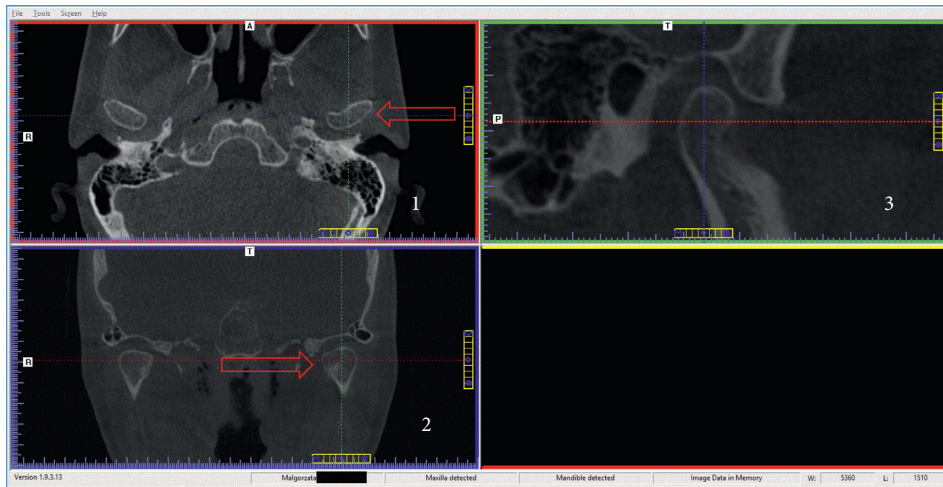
Steps of the petrotympanic fissure assessment of in the CBCT image.
